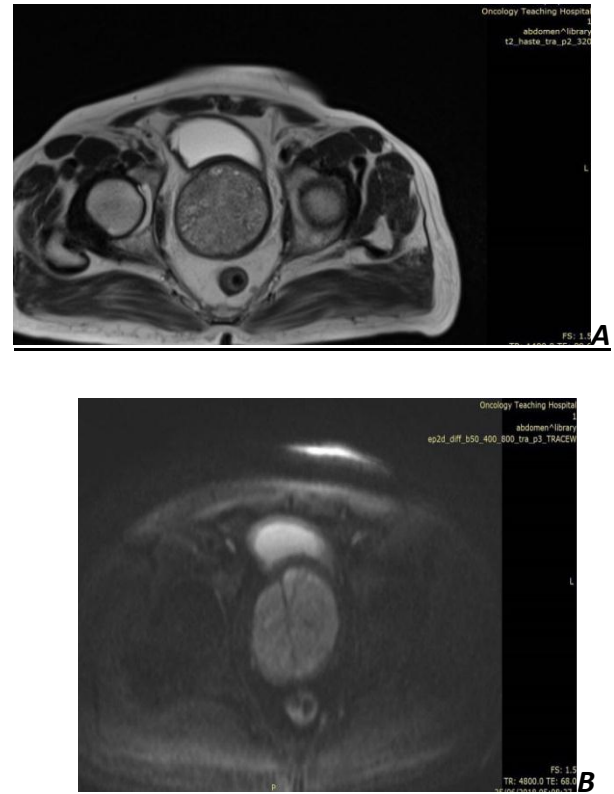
69 years old male presented with mildly elevated PSA level (about 7 ng/ml). Pelvic MRI T2WI (A) revealed enlarged prostate gland (markedly enlarged transitional zone with intact hypointense prostatic capsule, heterogeneous prostate gland signal intensity but no definitive focal lesion). (B&C) No abnormal restricted lesion on DWI and ADC image with average ADC value about $1300 \times 10^{-6} \text{ mm}^2/\text{s}$ in different areas of the prostate ...Picture was consistent with BPH.
